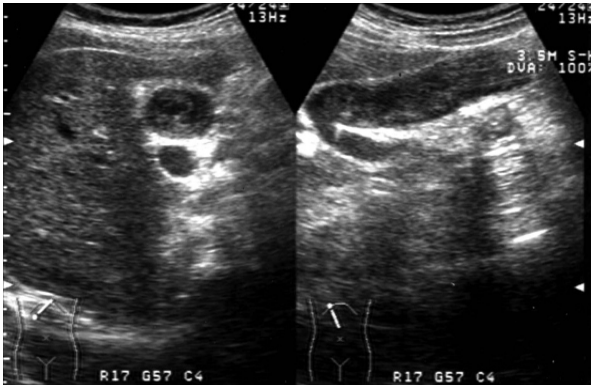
The abdominal ultrasonography showing an amorphous heterogeneous mass in cross and longitudinal sections of the gallbladder.
